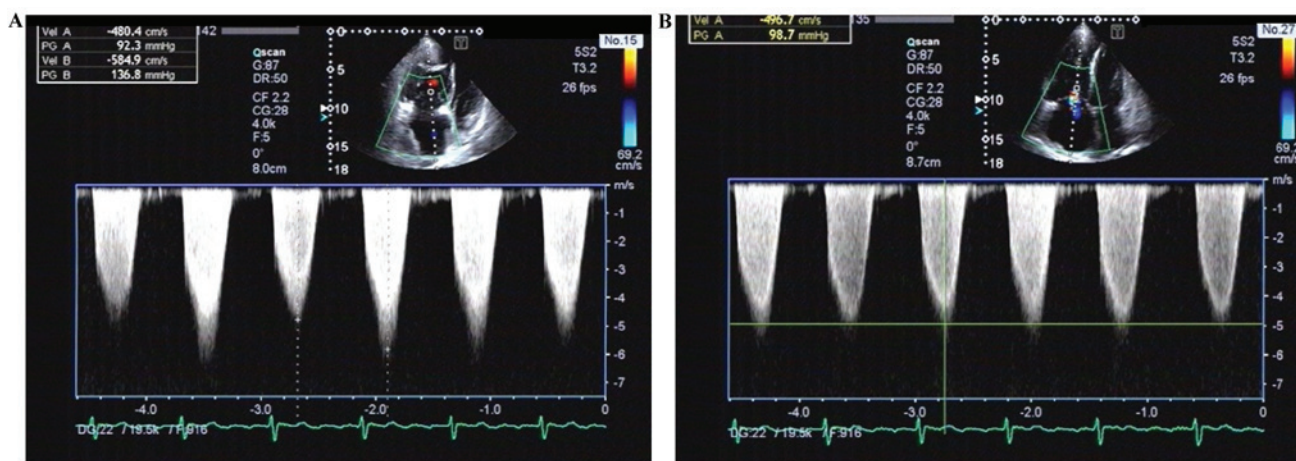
Echocardiography performed on a 33-year-old male with pulmonary hypertension. (A) During inspiration, tricuspid regurgitation Vel was 480.4 cm/sec with a PG of 92.3 mmHg. During expiration, tricuspid regurgitation Vel was 584.9 cm/sec with a PG of 136.8 mmHg. (B) At the end of expiration, tricuspid regurgitation Vel was 496.7 cm/sec with a PG of 98.7 mmHg. Vel, velocity; PG, pressure gradient.
